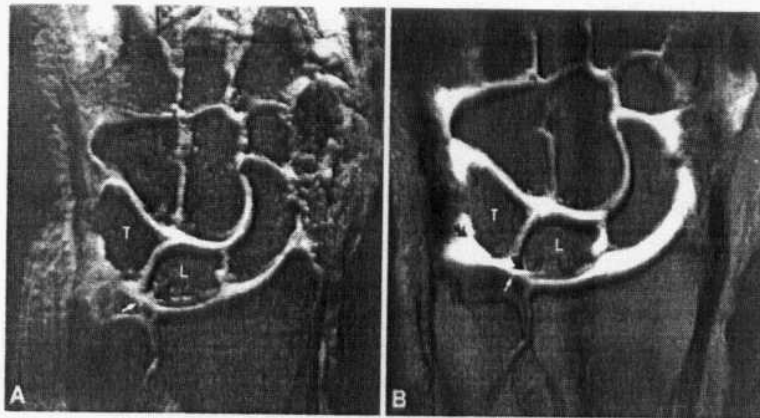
Class IIB lesion with degenerative fraying of the distal aspect of the TFC (straight arrow). There is chondromalacia of the lunate and triquetrum (curved arrow) without associated TFC perforation. The LT and SL ligaments are torn (A: T2*-weighted coronal image; B: fat-suppressed T1-weighted coronal MR arthrographic image(Quoted from Stoller and Brody, 1997).
